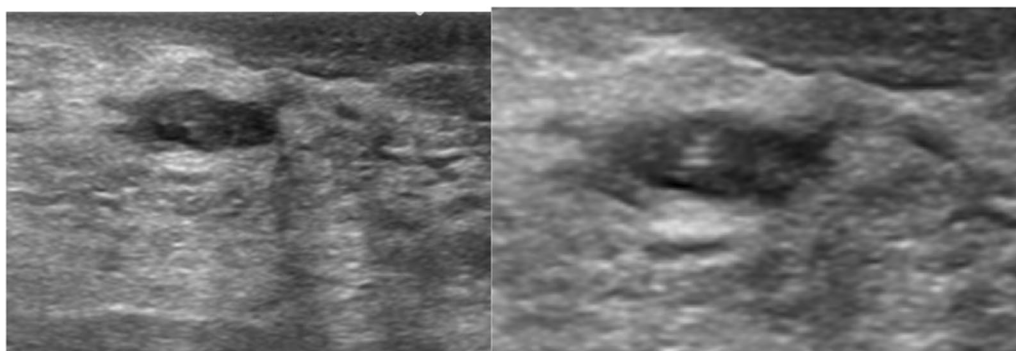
Serial of images from real-time ultrasound focused on targeted lesion in the right breast at 11 o'clock position
